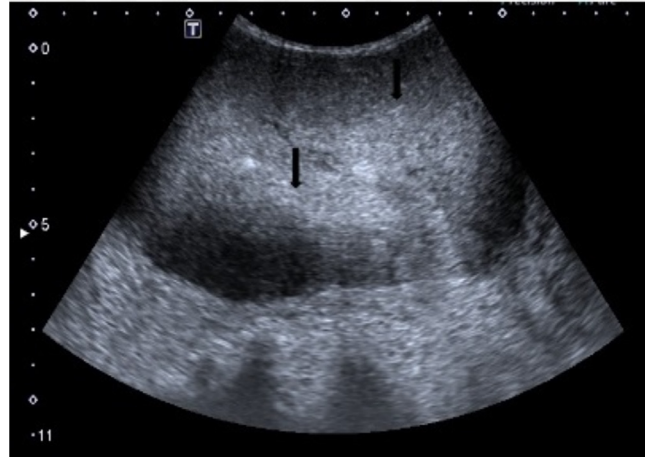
Ultrasonography shows lace like hyperechoic areas inside the mass lesion (black arrows)
